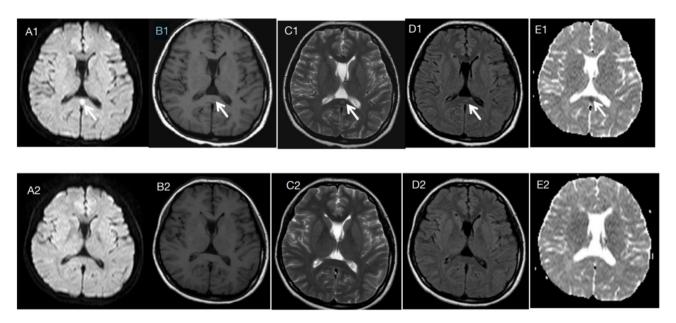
Brain MRI manifestation of RESLES: High signal in DWI sequence(A1); Slightly low signal in T1WI sequence(B1); High signal in T2WI sequence(C1-D1); Low signal in ADC(E1); The lesion in the corpus callosum disappeared on brain MRI examination after recovery(A2-E2). (A: DWI B: T1WI C: T2WI D: T2WI-FLAIR E: ADC)
